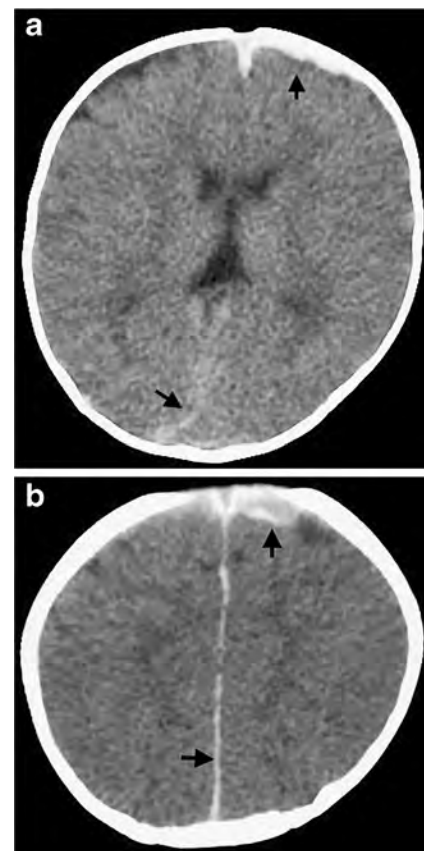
Lack of an age-different pattern despite a number of violent shakings admitted by the mother of this 5-month-old girl. a, b CT shows only a thin hyperdense subdural hematoma over the left frontal lobe and in the interhemispheric fissure (arrows). The brain edema may mask a previous hematoma
